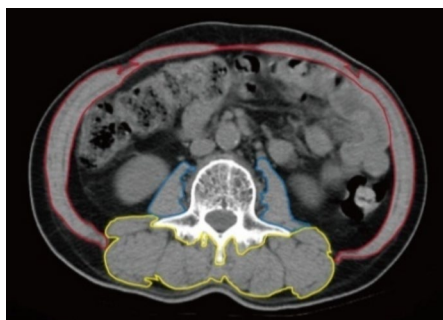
CT scan image analysis method of skeletal muscle at the third lumbar spine vertebra level
